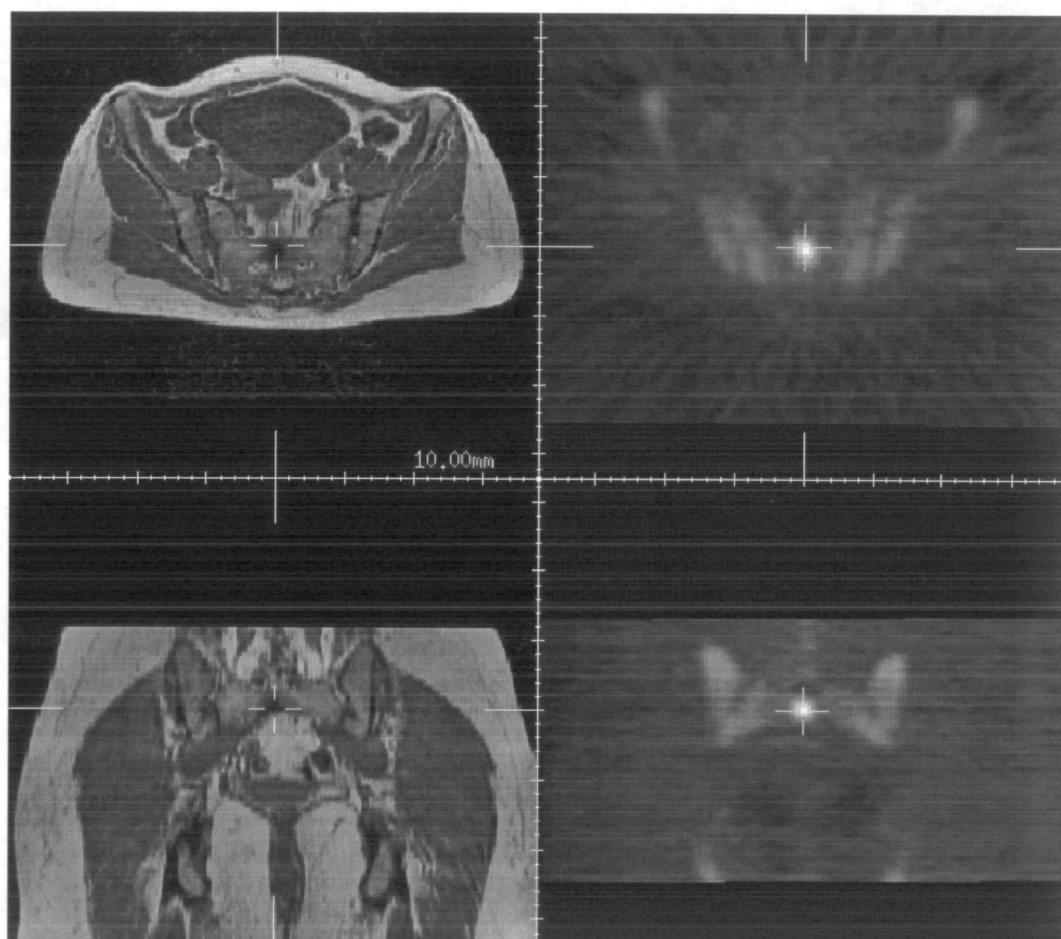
Corresponding transaxial (top) and coronal (bottom) slices from manually registered images showing different structures delineated by T1 weighted MR (left) and PET (right) scans of the pelvis. The PET image is of both ^{18}F FDG and ^{18}F - tracers which delineate both tumour and bone structure within the patient.
